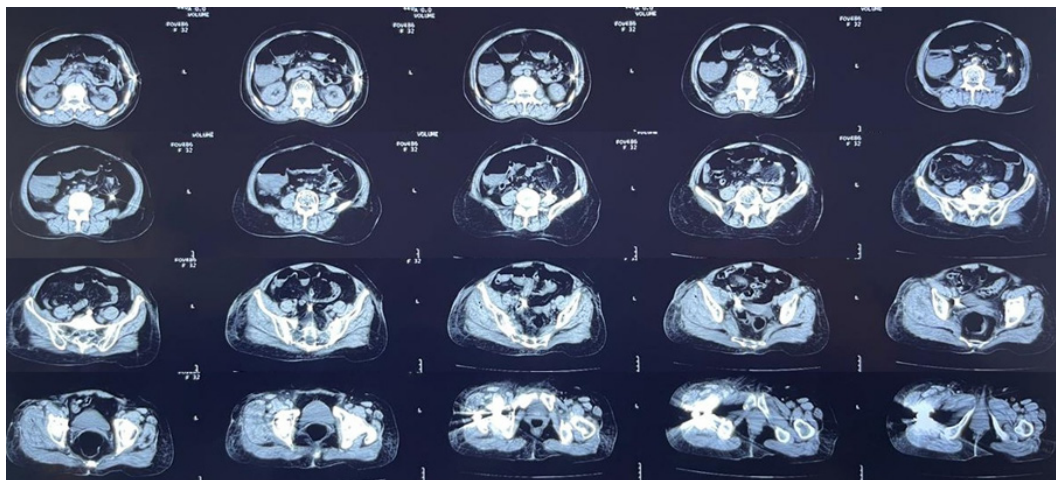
Abdominopelvic CT demonstrating a migrated osteosynthesis pin traversing the abdominopelvic cavity with dilatation of small bowel loops.
